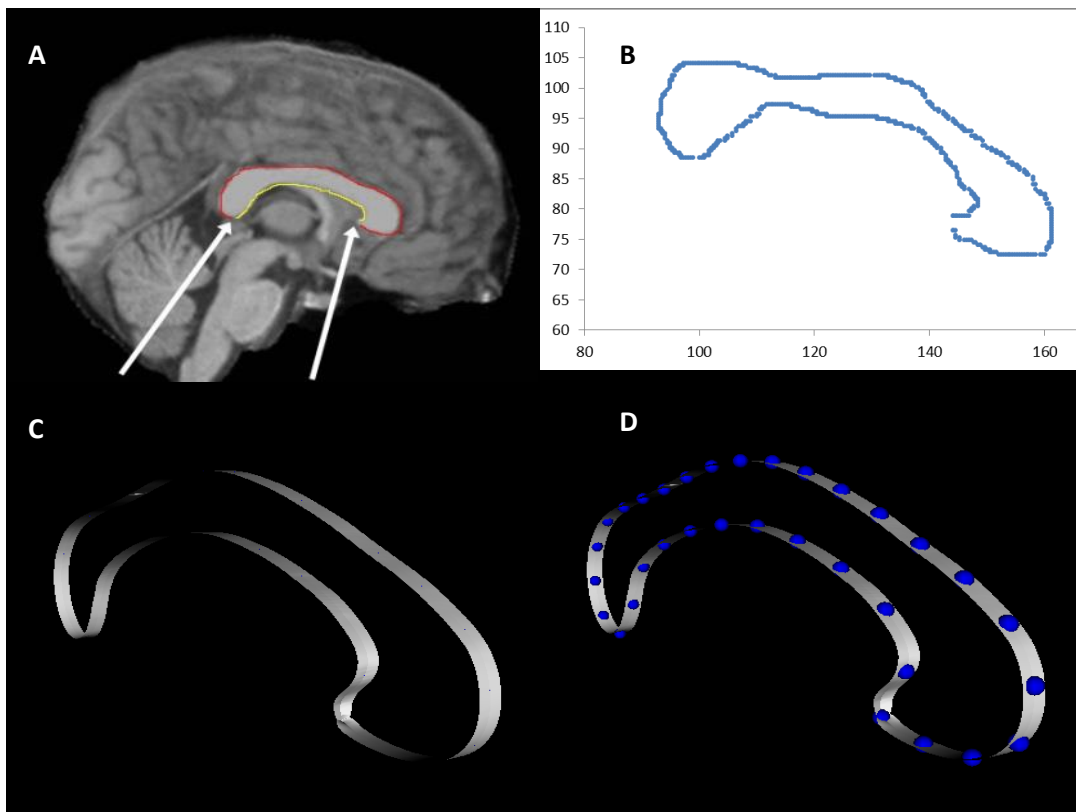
(A) Original contour outline on MRI, splenium and genu points (B) Plot of raw CC points in 2D from contour outline (C) 3D rendered and laplacian smoothed CC from raw points using additional equidistant vertices on x-axis (D) 33 landmarks including 35 semi-automatically induced equidistant semi-landmark points.
